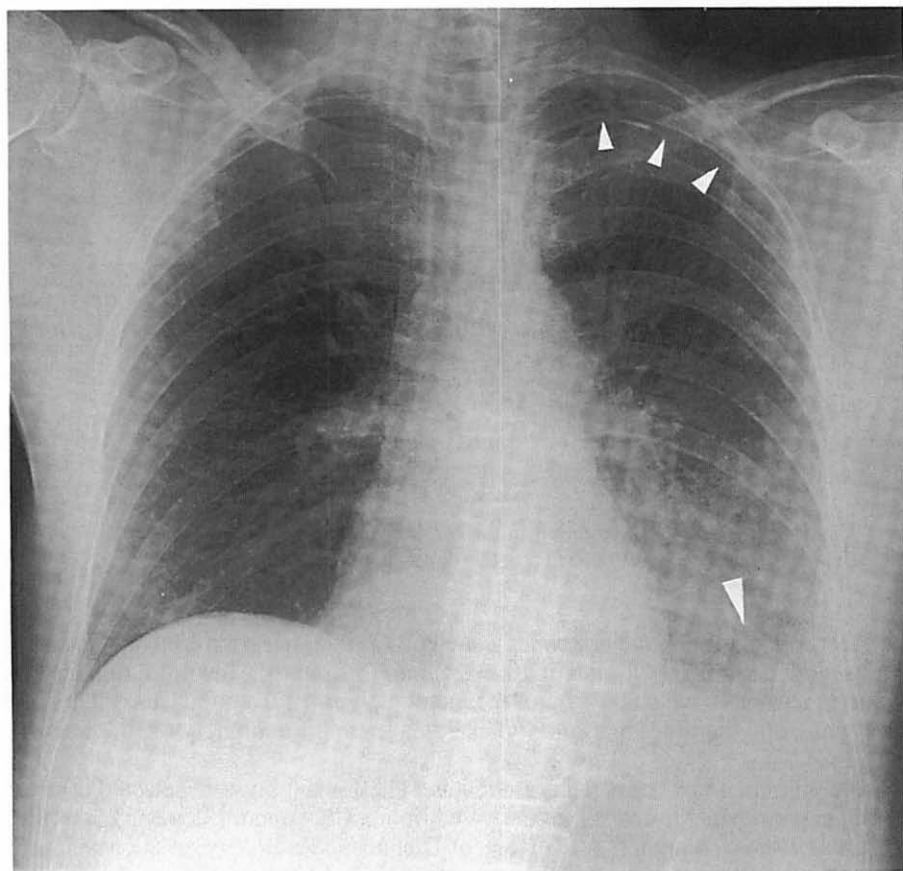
Ink jet printed radiograph on paper with a matrix of 1800 x 1760 pixels which gives a print size of 180 x 176 mm². The patient had a left apical pneumothorax and effusion in the left pleural cavity.
